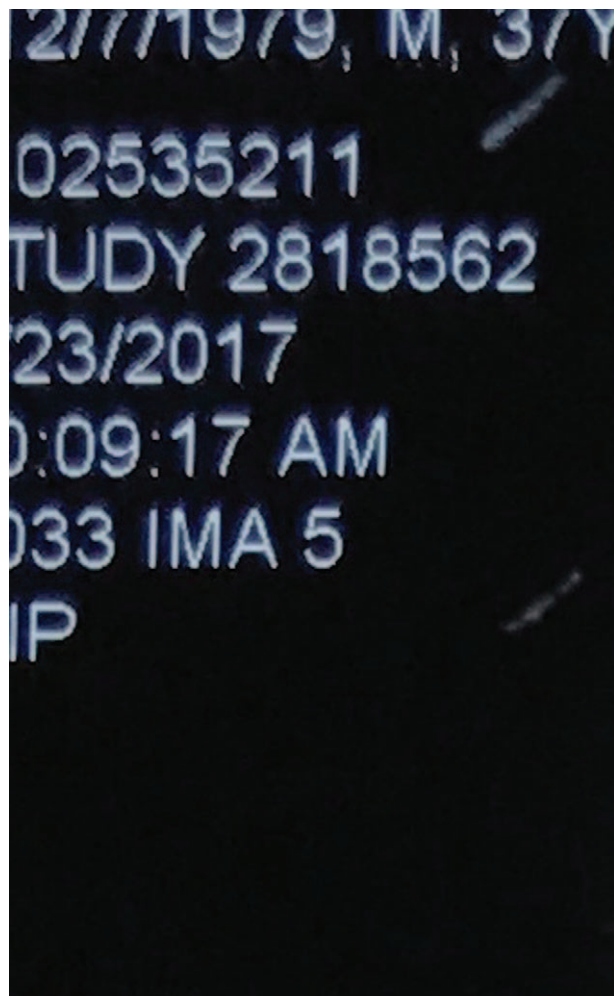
Three months later, the CTA showed no sign of the abnormal artery and the abnormal pulmonary parenchyma shrunk significantly. CTA= computed tomography angiography.
